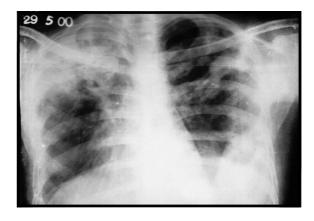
(a) Chest x-ray (PA view) shows the presence of left sided pleural effusion with non homogenous opacity in the right upper zone of the lung parenchyma. (b) Chest x-ray (PA view) shows increase in the size of the left sided pleural effusion compared with Figure 1 (a) along with the non homogenous opacity in the right upper zone.
